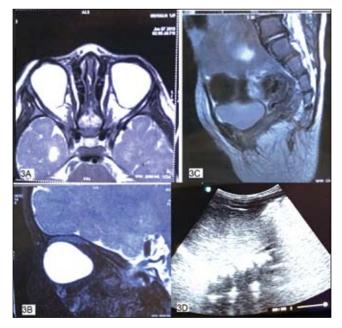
Elongated cystic eyeballs with no discernable cornea, lens, anterior chamber seen on contrast enhanced MRI(CEMRI) Fig 3C Anterior abdominal wall defect and mild herniation of small bowel loops seen on CEMRI pelvis Fig 3D: Ultrasound KUB: Right renal agenesis
